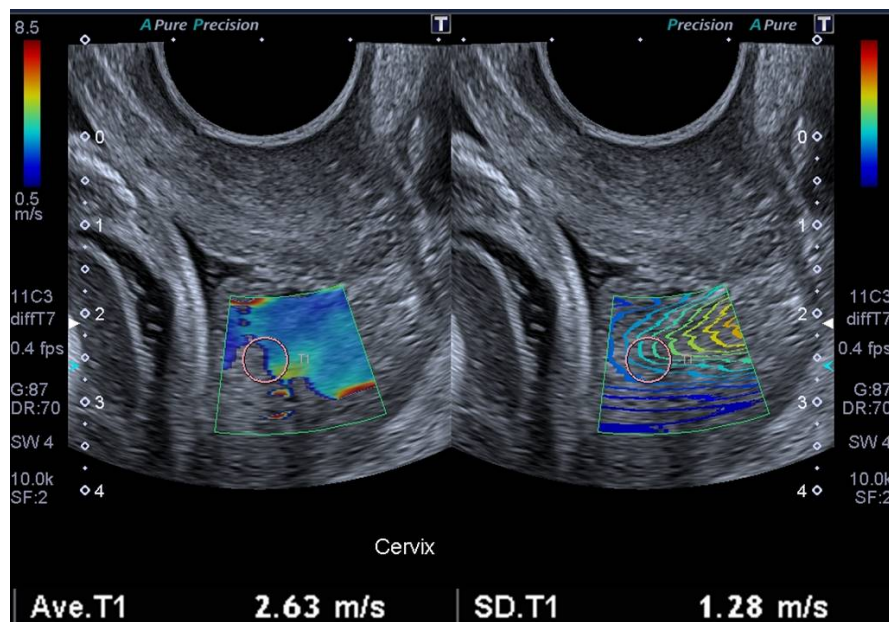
Example of loss of shear wave propagation shown in the posterior portion of the internal os using the transvaginal ultrasound approach, demonstrating loss of elastogram filling and erratic propagation lines and a high SD of 1.28m/s.
